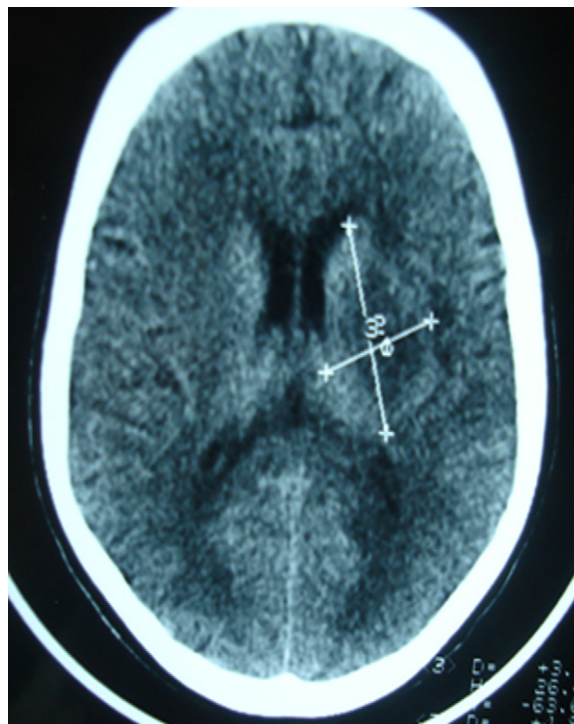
Axial nonenhanced CT scan shows infarct with edema in deep territory of left MCA distribution.
